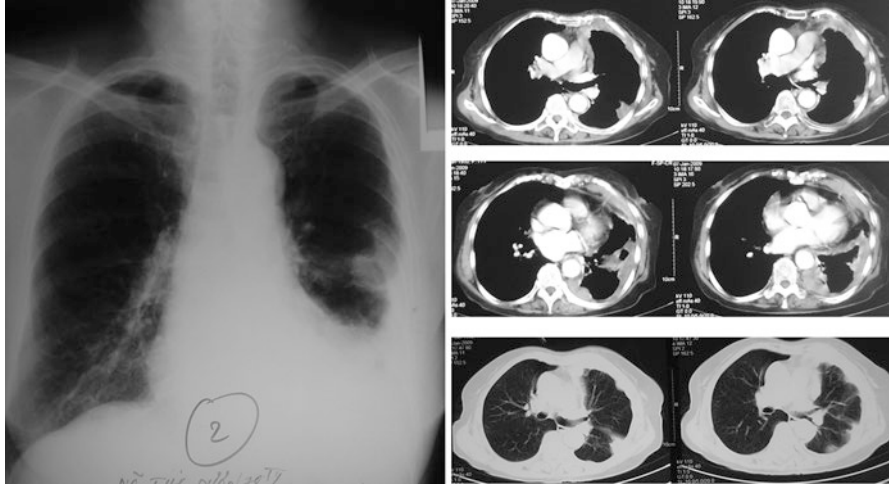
Chest X-ray and CT images of a 77-year-old female patient with pleural malignant mesothelioma. The chest X-ray shows mild left pleural effusion accompanied with mild volume reduction of the left hemithorax. The chest CT images in mediastinal window show mild left pleural effusion and localized pleural thickenings which cause mild volume reduction of the left hemithorax. The chest CT images in parenchymal window show rind-like encasement of the left hemithorax
